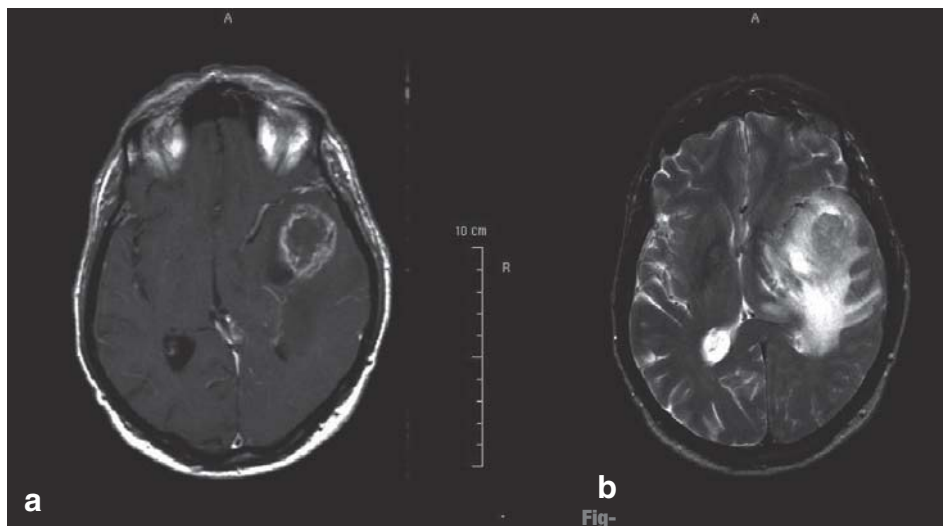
Magnetic resonance images of a glioblastoma: centrally necrotic mass with strong peripheral contrast enhancement and marked peritumoral edema
